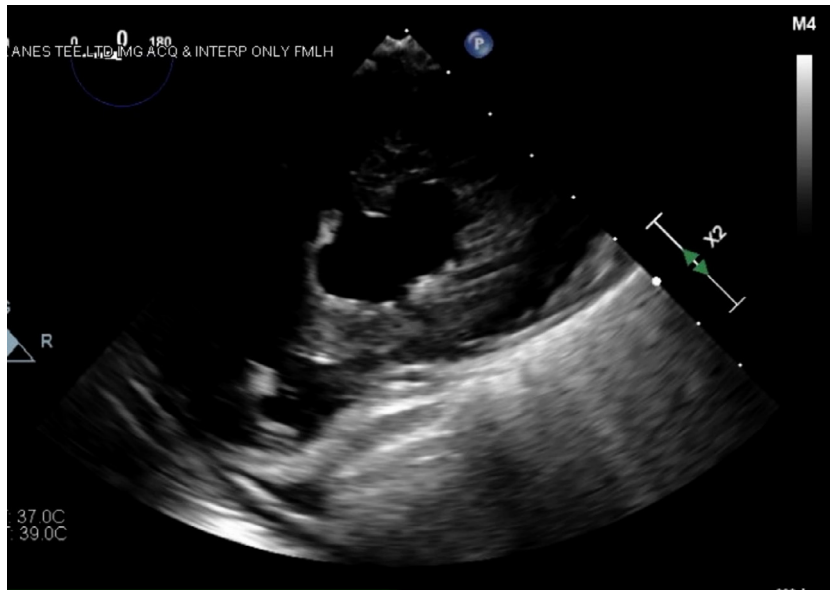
Transgastric midpapillary short axis transesophageal echocardiography view showing left ventricular flattening during diastole.
